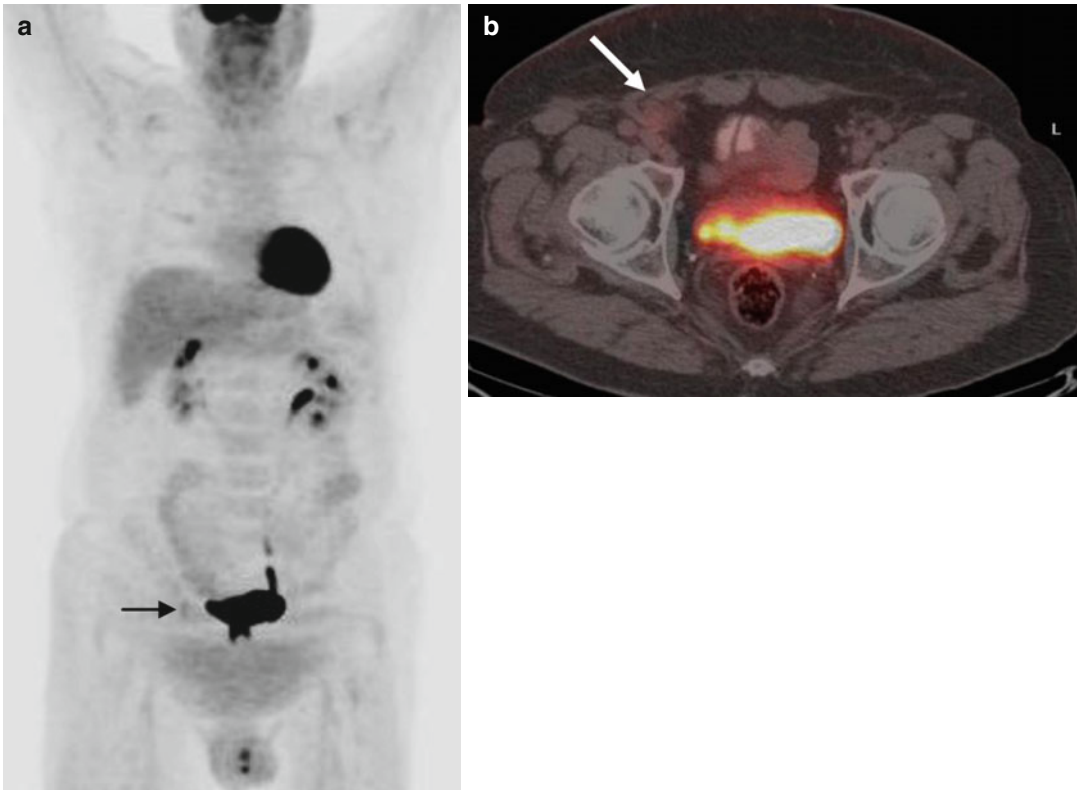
(a, b) MIP-PET and fused PET/CT – end of chemoimmunotherapy: Mild FDG uptake at a *right* inguinal lymph node (arrows), not exceeding the uptake of the liver (D5-PS score 3)
